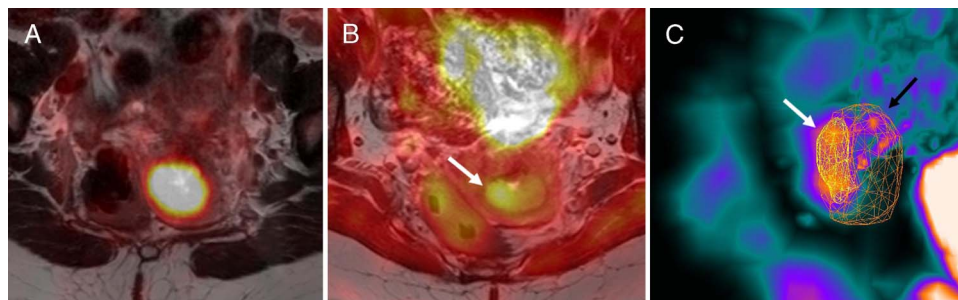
^{18}F -EF5 and ^{18}F -FDG PET/MRI scans of patient 6. A, ^{18}F -FDG PET/MRI transaxial fused image shows the metabolically active cervical tumor. B, ^{18}F -EF5 PET/MRI (T2-weighted TSE) transaxial fused image (same level as in A) shows ^{18}F -EF5-avid area in the right side of the tumor (white arrow). C, In 3-dimensional ^{18}F -EF5 PET image, the solid yellow area (white arrow) represents the HS inside of ^{18}F -FDG positive tumor (black arrow).
